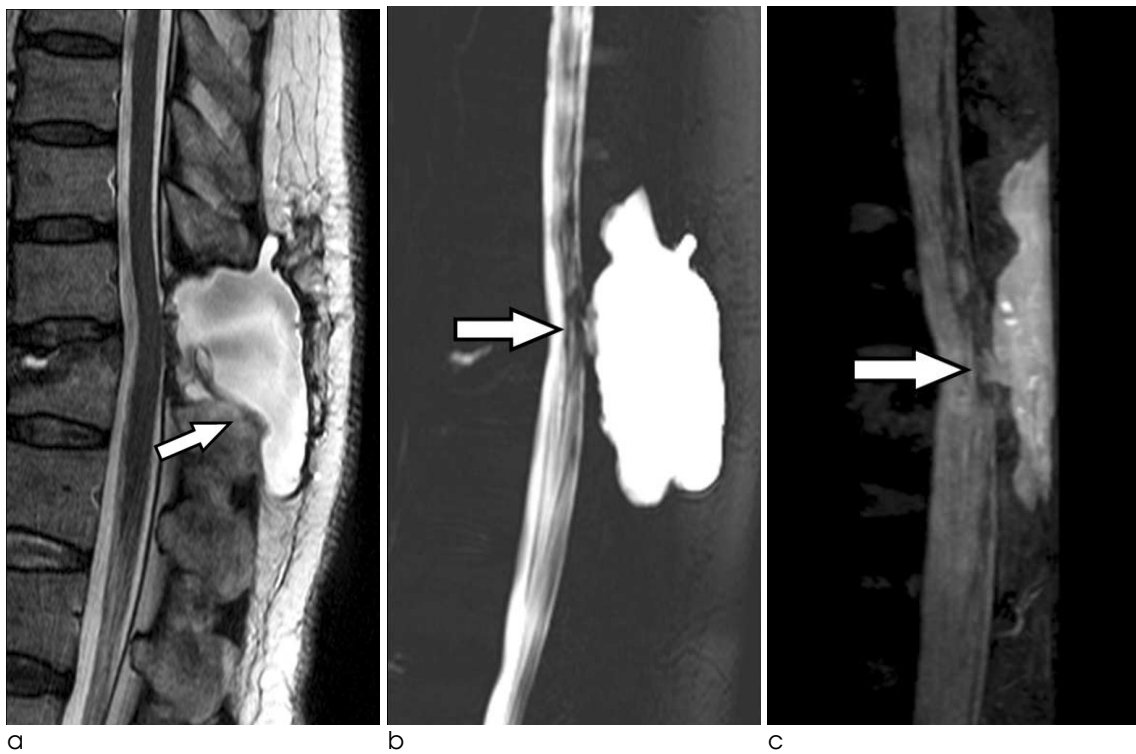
Patient 2, a 64-year-old woman with orthostatic headache after resection of an intradural meningioma. (a) Postoperative T2-weighted sagittal image shows extradural fluid collection (arrow), but not the exact site of communication. 2D TSE sagittal (b) and MIP image of 3D BTFE MR myelography (c) show communication at the T12 level (arrow). (d) Axial reconstructed 3D BTFE image showing the defect on the left side of the thecal sac. (e) Intraoperative photograph of patient 2 shows that the dural defect (arrowheads) was located on the left side of dural sac and measured about 20 mm in length. The spinal cord is visible through the defect (Direction; H: head, F: foot).
